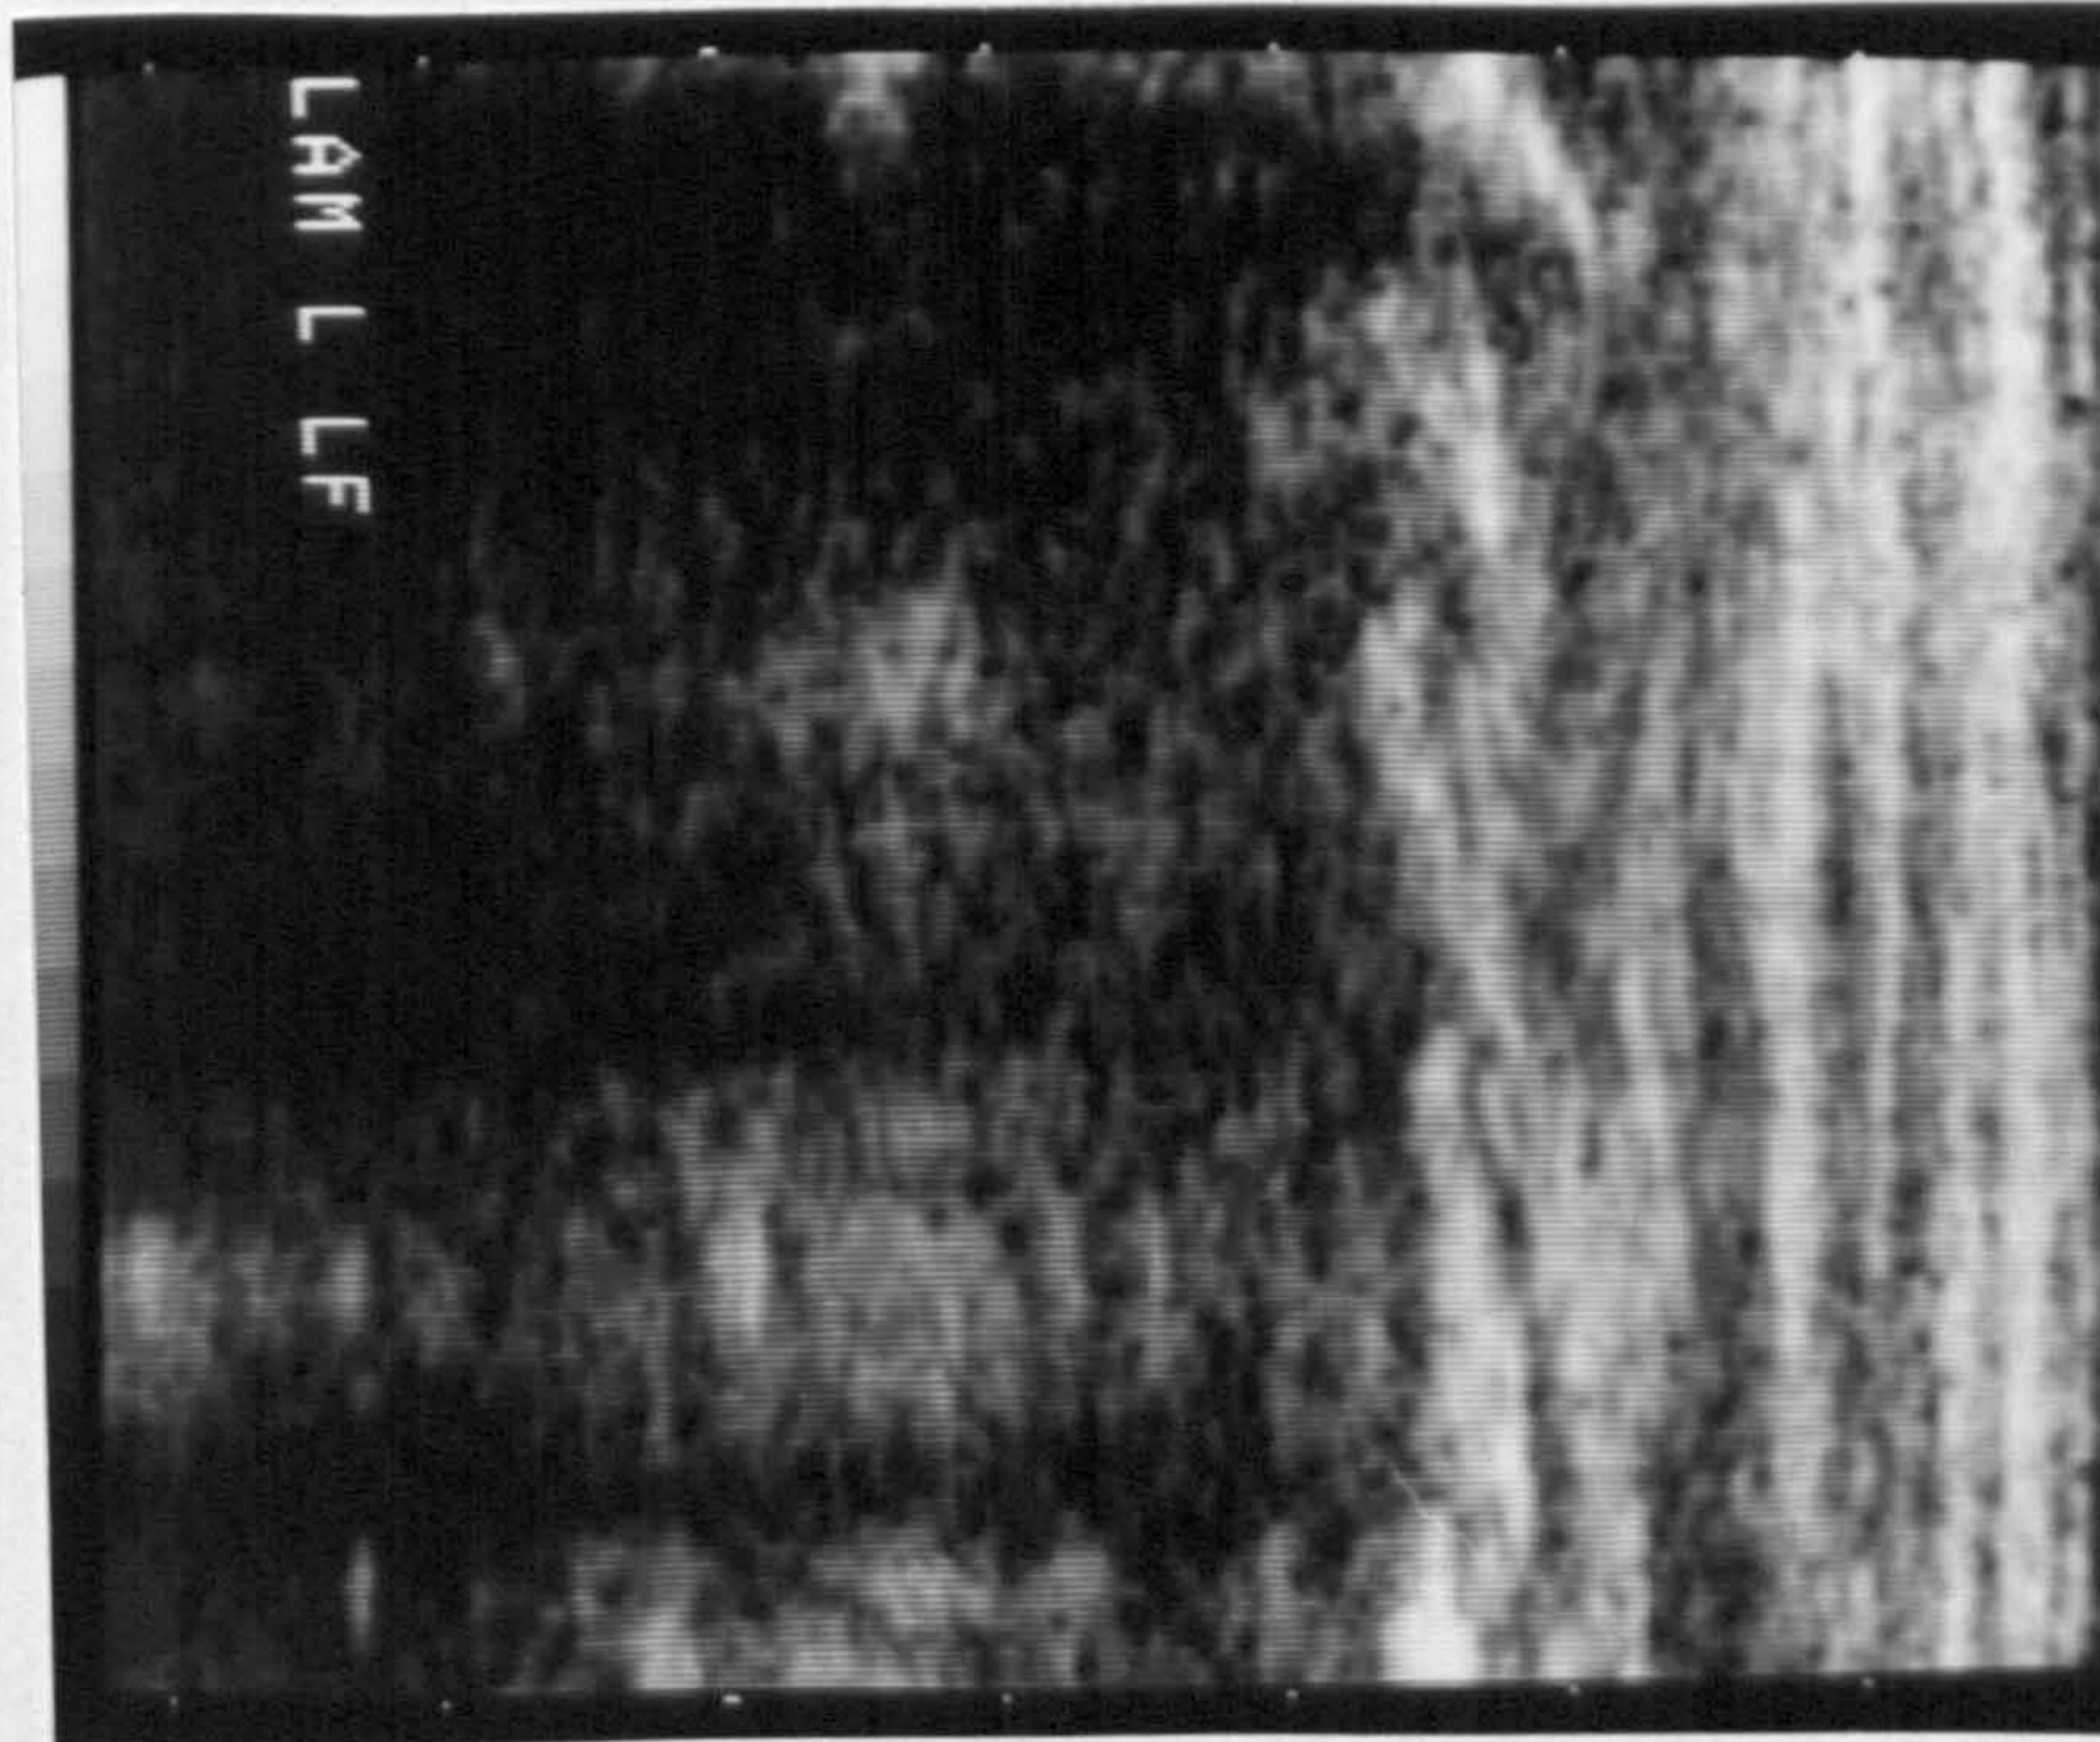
b Ultrasound scan lamina : posterior - lateral view
